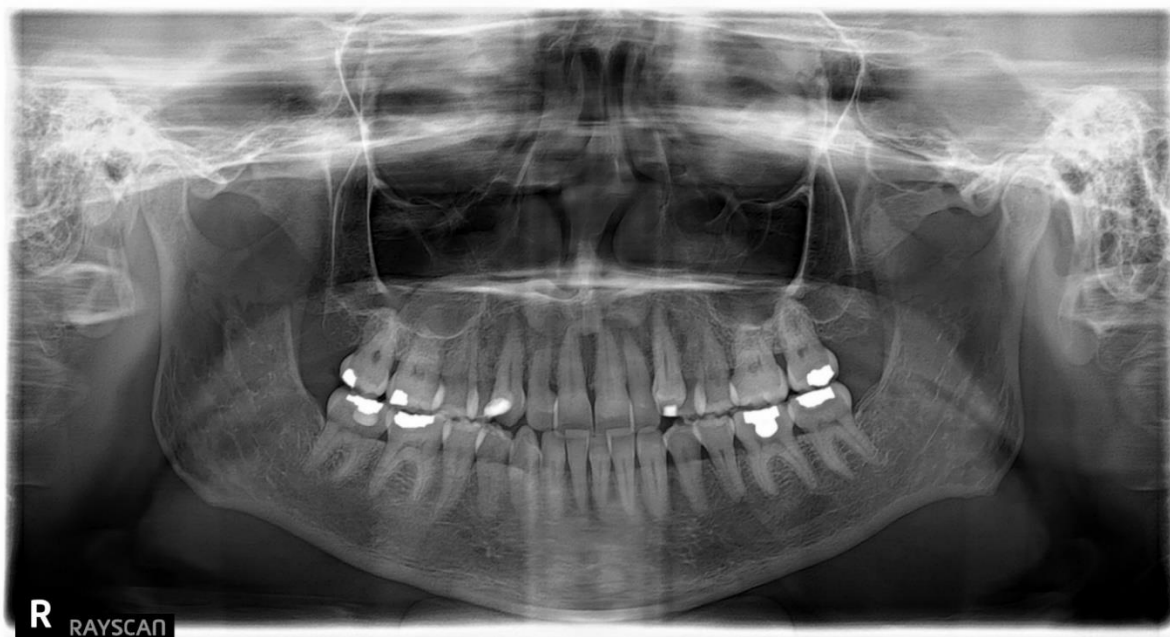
Panoramic radiograph 20 months post-op.
